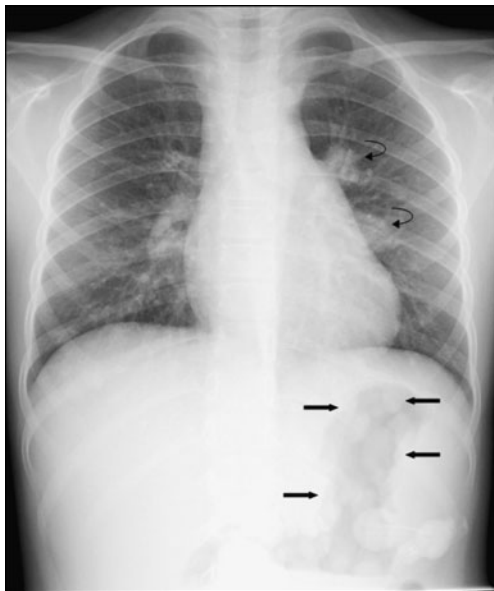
Frontal chest radiograph
